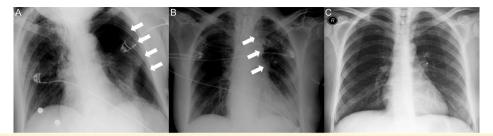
A-C. (A) Chest x-ray after tracheostomy shows left-sided tracheostomy and white arrows indicate the edge of collapsed left lung. (B) Chest x-ray shows re-expansion of the left lung after needle decompression and white arrows indicate the chest tube line. (C) Chest x-ray on discharge shows nearly normal lungs.
